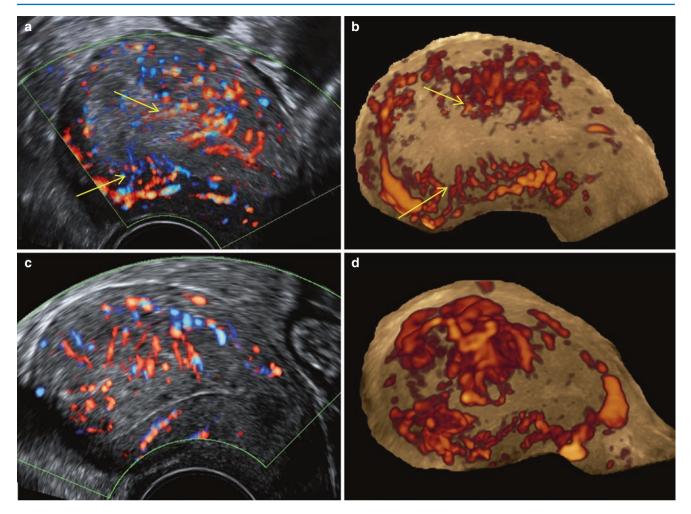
Benefit of 3D power Doppler with glass body display is primarily to detect vascular morphology of tortuous vessels that don't flow along a single plane. Linear vessel flowing along a single plane and can be seen pretty well even on 2D Doppler. (a, b) Flow in normal secretory endometrium (a) regular 2D Doppler showing linear vessels crossing the EMJ (*arrows*), (b) 3D – glass body display shows the same linear vessels crossing the EMJ (*arrows*). (c, d) Case of endometrial malignancy (c) regular 2D Doppler showing colour signal dispersed in the endometrium (most of the vessels could not be traced along their length). Only a few linear vessels crossing the anterior EMJ can be traced. (d) 3D – glass body display shows the tortuous path of the endometrial vessels and the abnormal vascular tree. The few linear vessels crossing the EMJ seen in (c) are also seen
